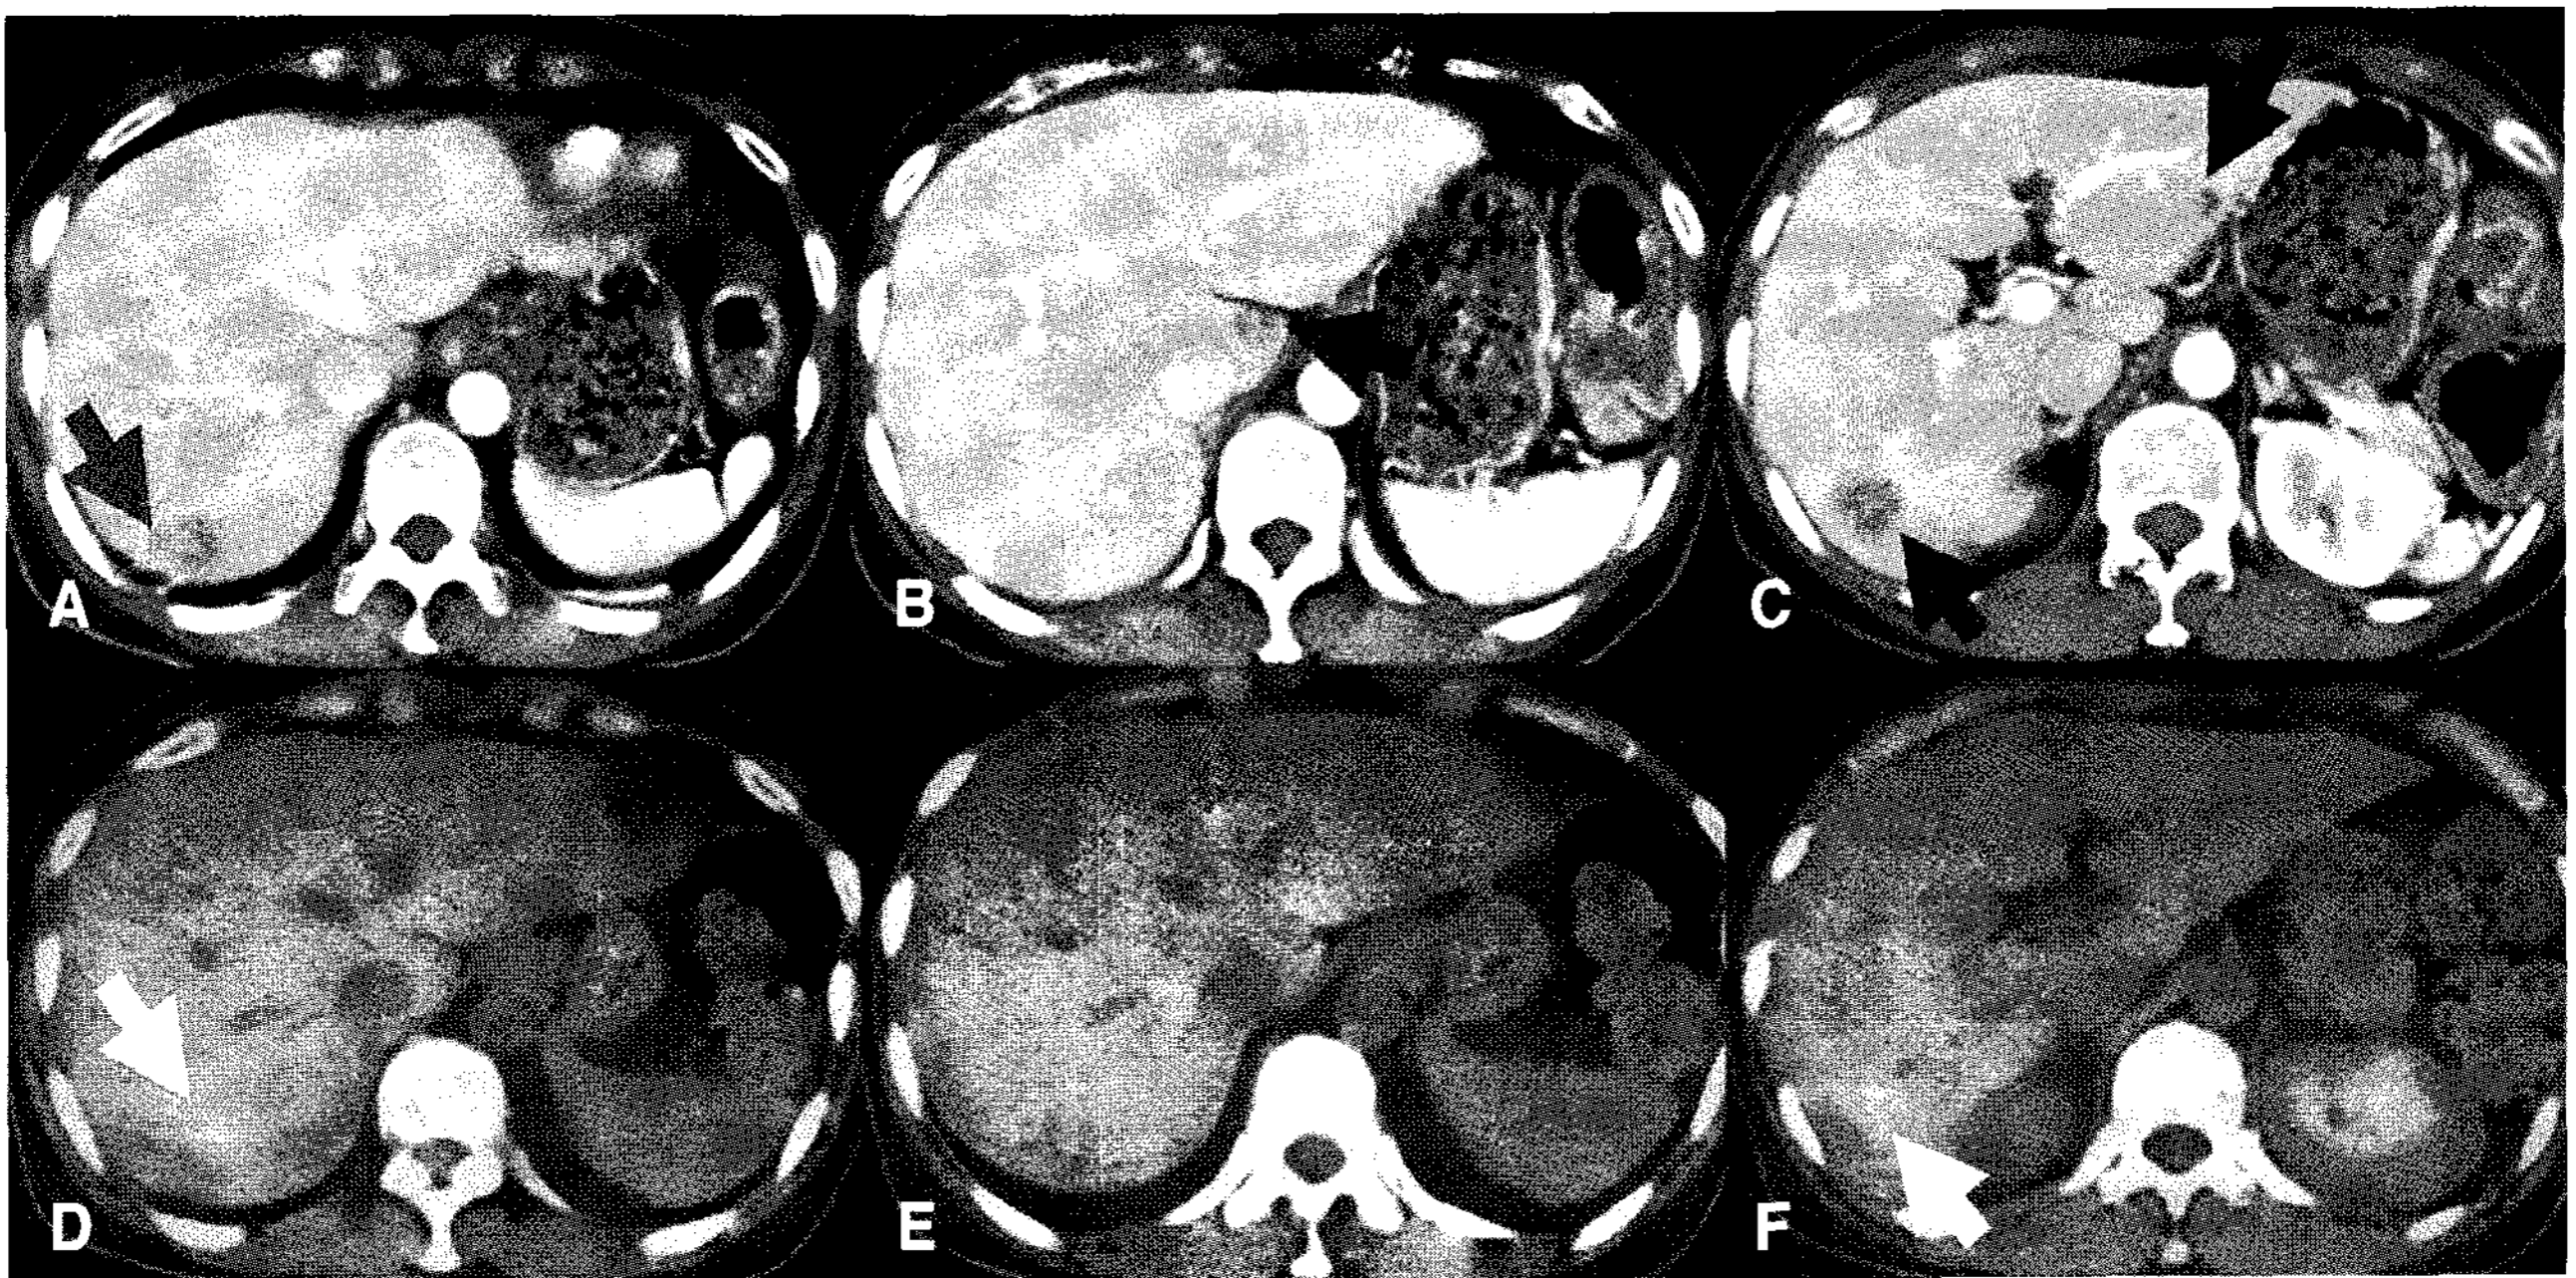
CT images (A, B, C) of this 53 year old patient with adenocarcinoma of ovary who received extensive surgery and chemotherapy until 4 months ago show low density lesions in both hepatic lobes and caudate lobe, suggesting multiple liver metastasis (arrows). PET/CT (D, E, F) demonstrates focal FDG uptake (SUVmax 3.6) in right hepatic lobe (arrows). However, the patient's tumor marker CA 125 titer remained low at 3.71 IU/mL. Re-operation confirmed metastatic endometrioid adenocarcinoma.
